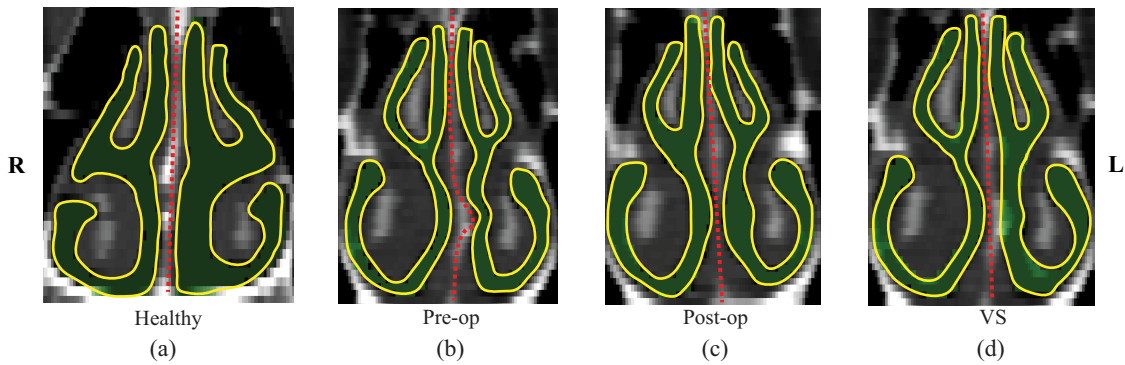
The coronal cross-sectional CT images present the segmented nasal airway of the healthy nose (a) and DNS patient #1's pre-operative nose (b), post-operative nose underwent septoplasty and turbinate reduction (c), and virtual-surgery (VS) model based on septoplasty alone. Dashed lines represent shapes of the septal cartilages. R and L are the right and left side of noses
